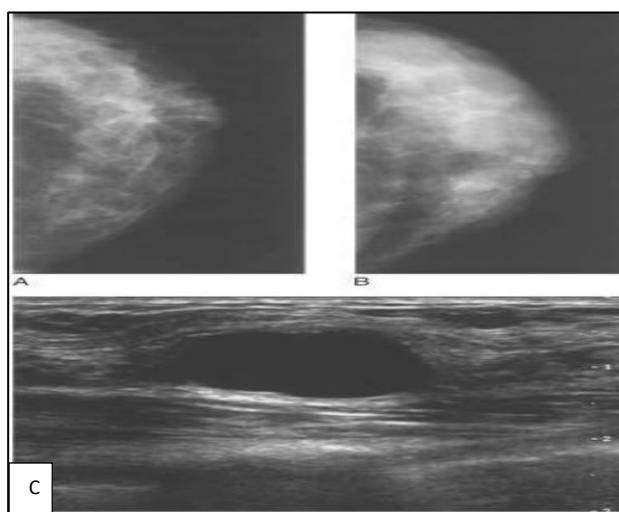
(A-C): Mammographic and ultrasound images in breast cancer.
